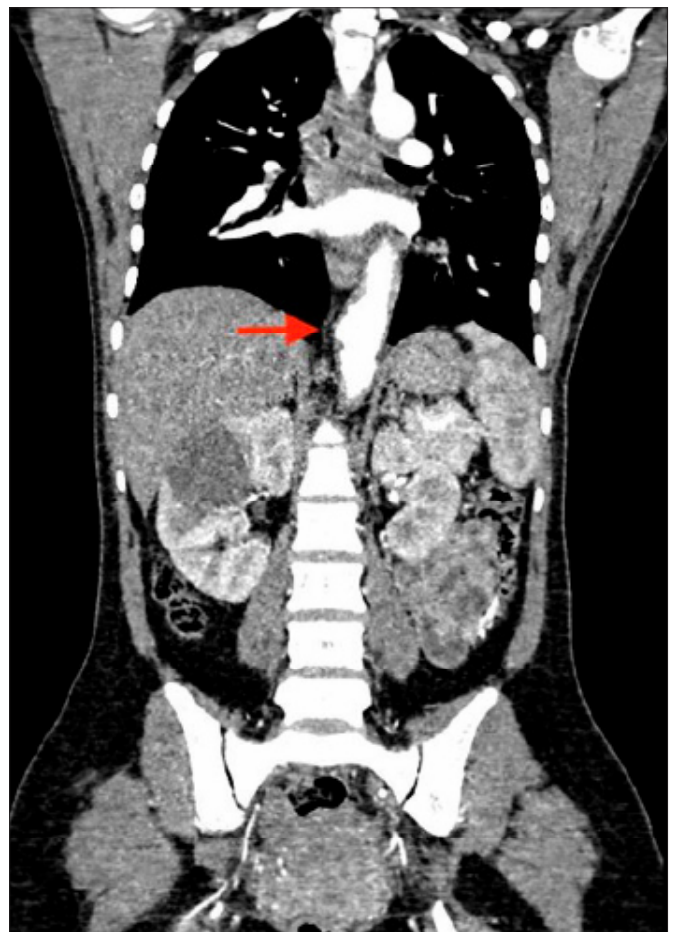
CT Angiogram showing aneurysmal dilatation of the thoracic aorta
